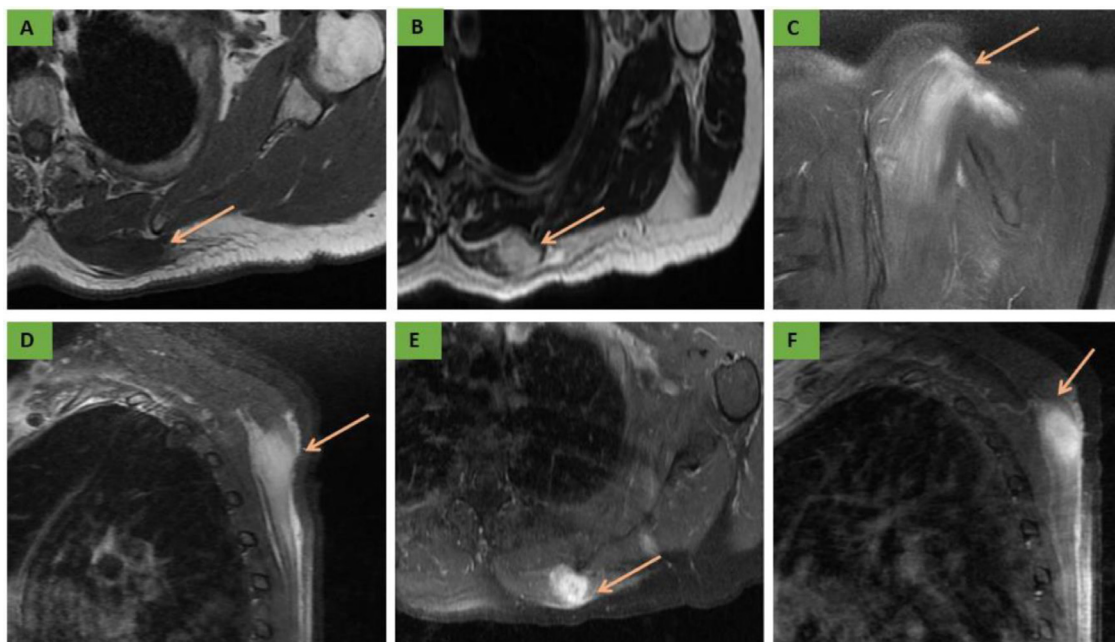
MRI appearances of proliferative myositis. • Mass developed within the large musculus latissimus dorsi, presented with iso signal to the muscle on axial T1 weighted images (A), hypersignal on axial T2 weighted images (B). • The pattern of preserved continuous muscle fibers is a specific finding in PM more marked on coronal DP (C), and sagittal DP (D) with fat saturation. • The sequences after intravenous administration of gadolinium (E, F) showed homogeneous enhancement of the lesion.
